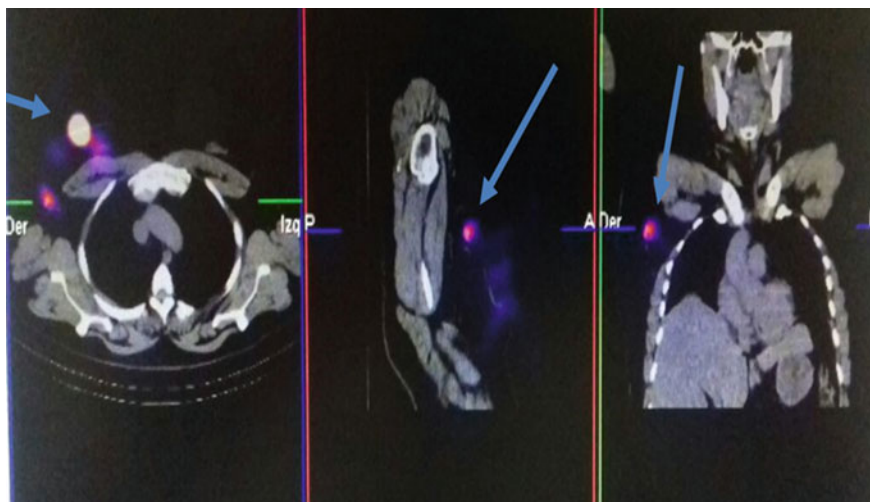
Sentinel node localization by SPECT/CT in patient with breast cancer (24 h ^{99m}Tc -AuNP-mannose post-administration). Image courtesy of National Cancer Institute (Mexico)
